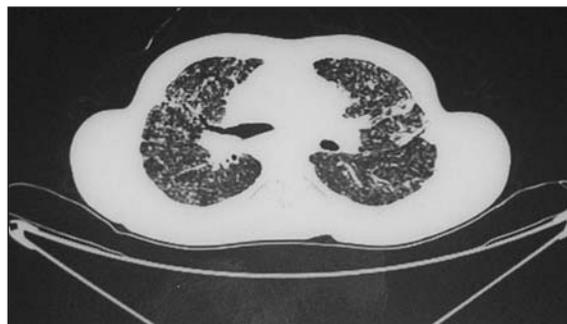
HRCT of 2<sup>nd</sup> case: Millimetric nodules in pulmonary parenchyma, interlobular septal thickness, increased reticular image and bilateral hilar lymphadenopathy.
